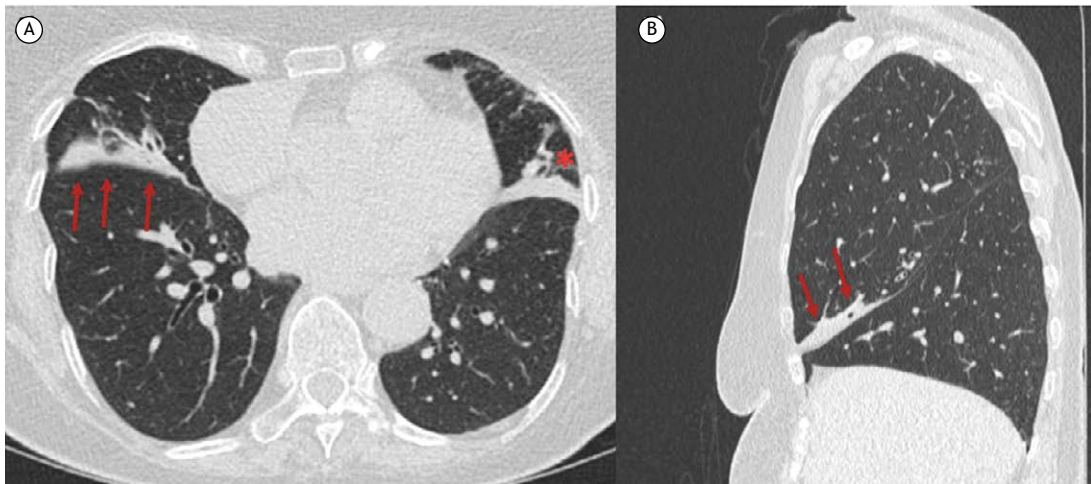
In A, an axial CT scan with lung window settings revealing atelectasis of the right middle lobe (arrows) and lingula (asterisk). In B, a coronal CT scan with lung window settings showing a slight displacement of the oblique fissure, bronchi, and adjacent vessels (arrows).
